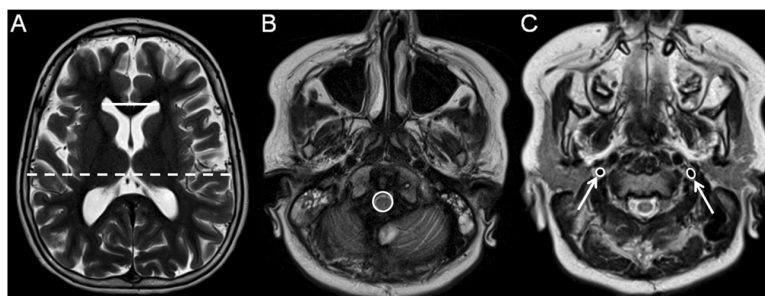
Axial T2-weighted images of an 8-year-old boy with achondroplasia showing a bifrontal horn width (white line) and biparietal diameter (white dashed line) measurement; b foramen magnum surface area
